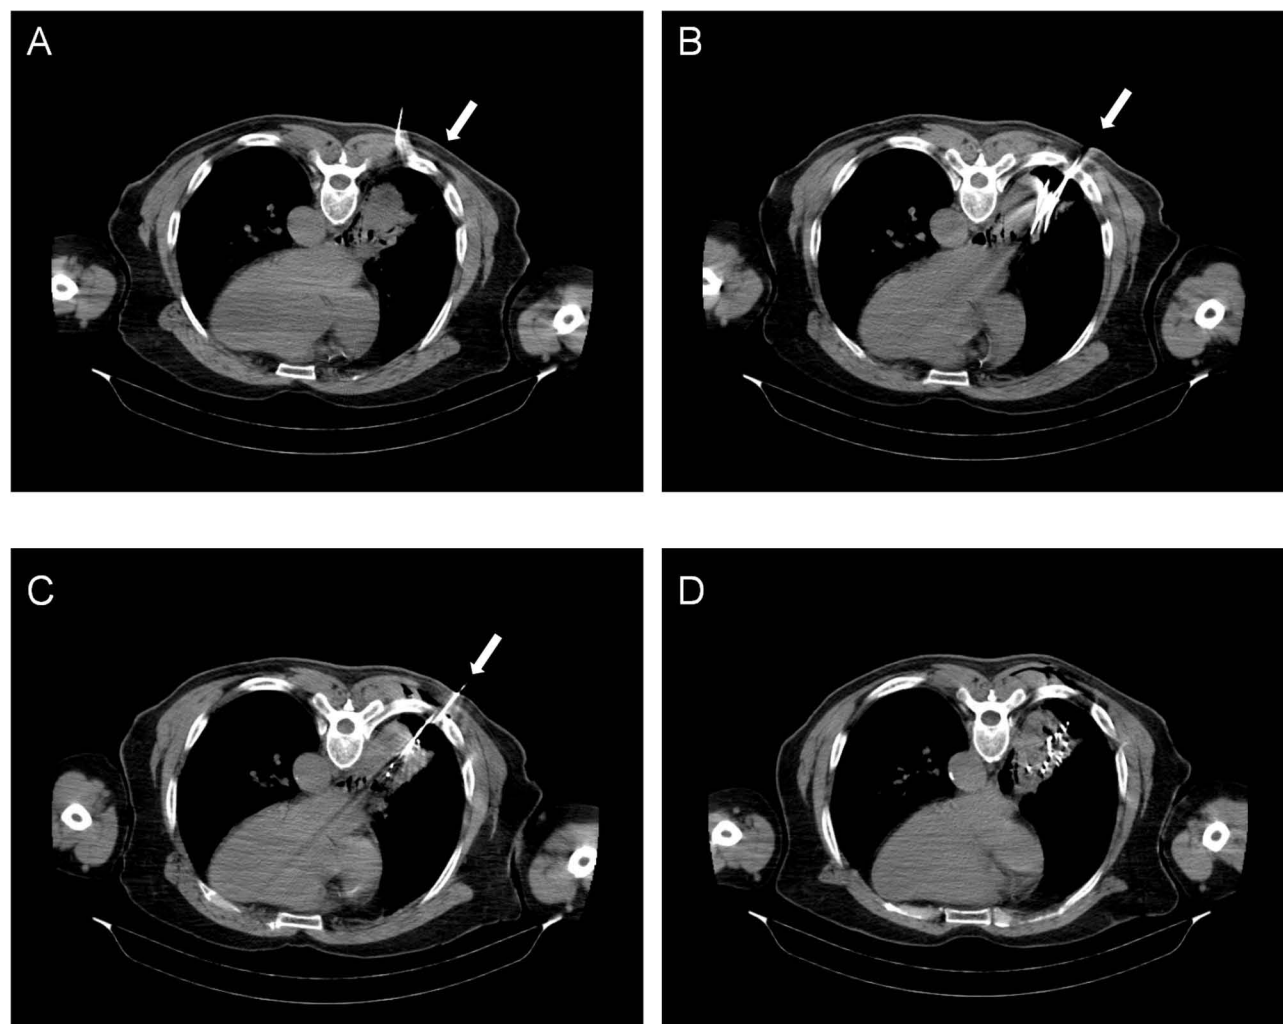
(A–C) The procedure of particle implantation performed with the patient in a prone position under CT guidance. The arrows indicate the needle insertion trajectory. (D) Post-procedural imaging confirming the homogeneous distribution of implanted particles within the target lesion.
